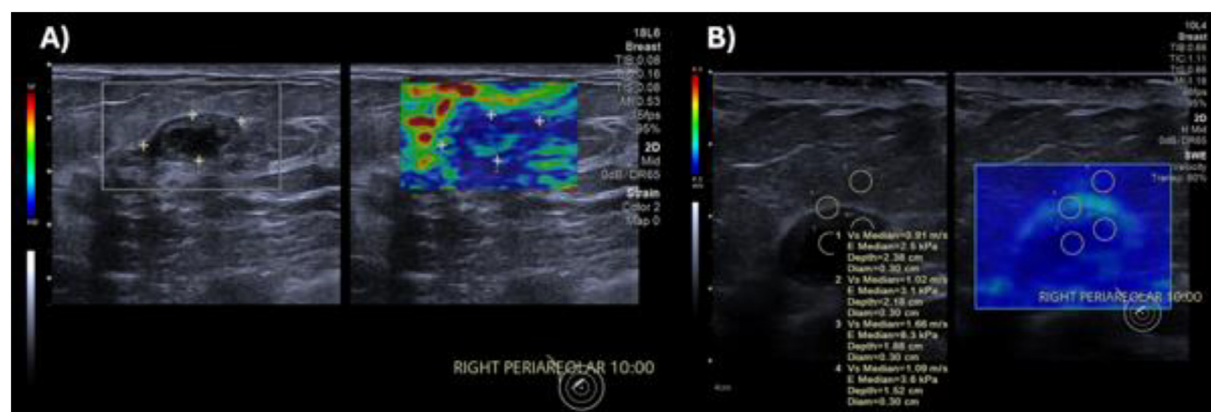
Ultrasound elastography. (A) Strain elastography showed mosaic pattern with Tsukuba 2 score. (B) Shear wave elastography showed normal reading of the thickened wall which as 3.1kPa.
